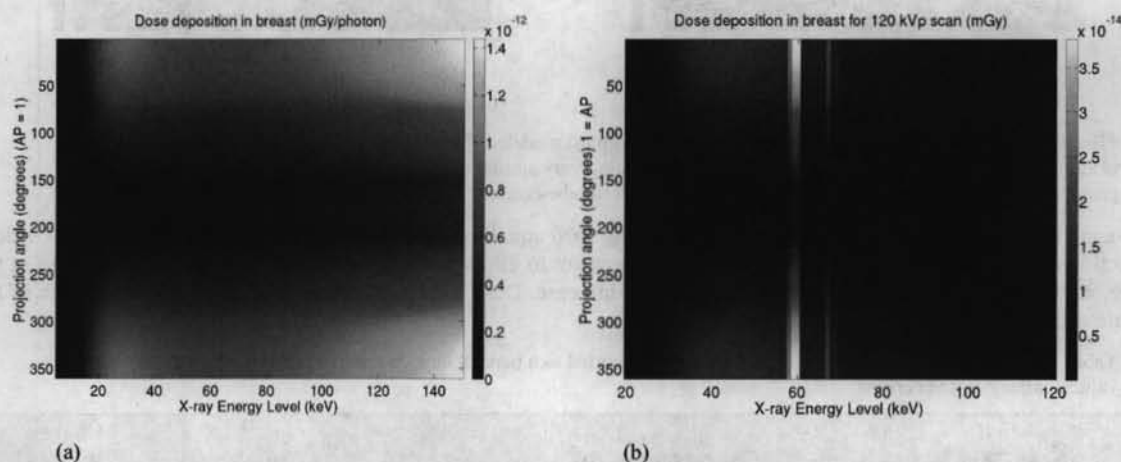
(a) The normalized dose deposition matrix,  $Q(\theta, E)$ , quantifies dose in breast tissue (mGy/photon) for each energy level and projection angle of single CT rotation. Energy levels range from 5-150 keV in 1 keV increments, and projection angles range from 1-360 degrees in 1-degree increments. Other scan parameters are source-to-detector distance of 100 cm, source-to-isocenter distance of 50 cm, and detector z-extent of 16 cm. (b) The non-normalized dose-deposition matrix,  $D(\theta, E)$ , quantifies dose in breast tissue (mGy) for each energy level and projection angle of a specific scan protocol. The figure shown is the dose deposition matrix for a reference 120 kVp scan.
